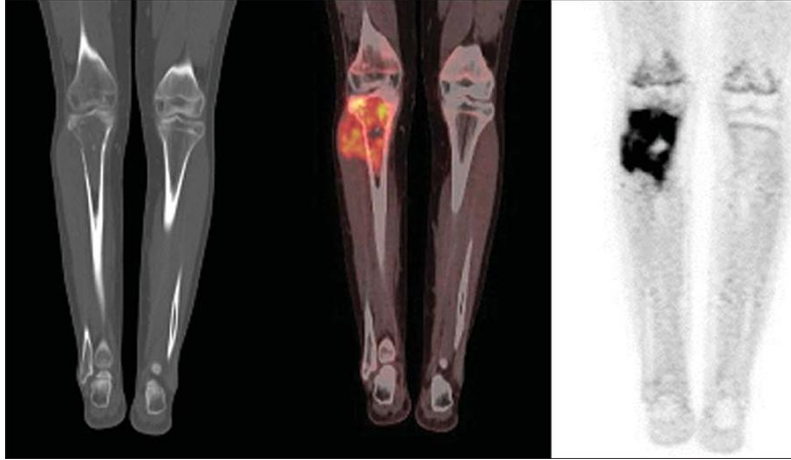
PET/CT image (middle) of patient diagnosed with Ewing's sarcoma. The CT image excels in delineating bone structure but provides only limited contrast in soft tissue parts. Image from [88] under CC-BY-NC.
